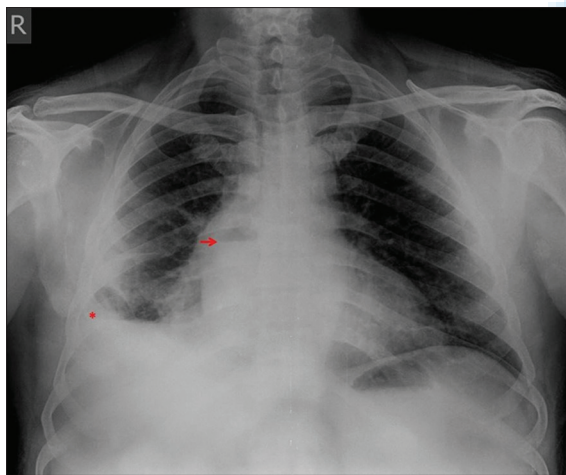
Frontal chest radiograph shows volume loss with an air fluid level in the right retrocardiac region (arrow). There is also right costophrenic angle blunting (asterisk) with thickening of the right minor fissure
